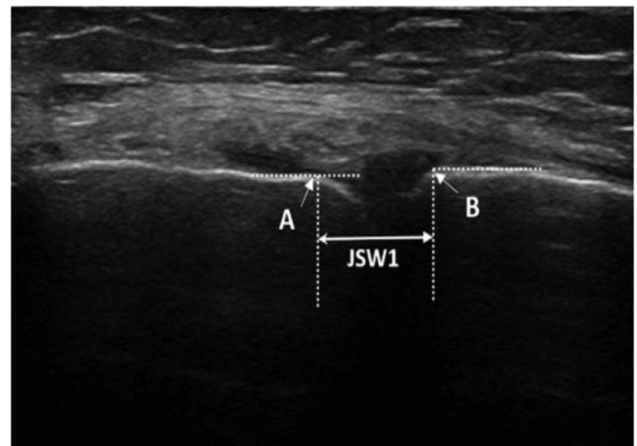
Method of joint space measurement on Ultrasound. Point A refers to the point of inflection in the femoral condyle and point B refers to the tibial end. JSW refers to the joint space width^[11].
